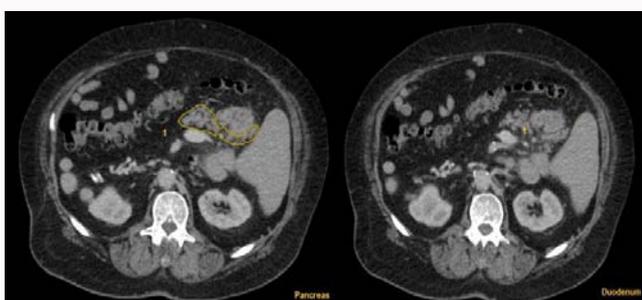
CT image showing envelopment of the duodenum by pancreatic tissue, suggestive of annular pancreas.
